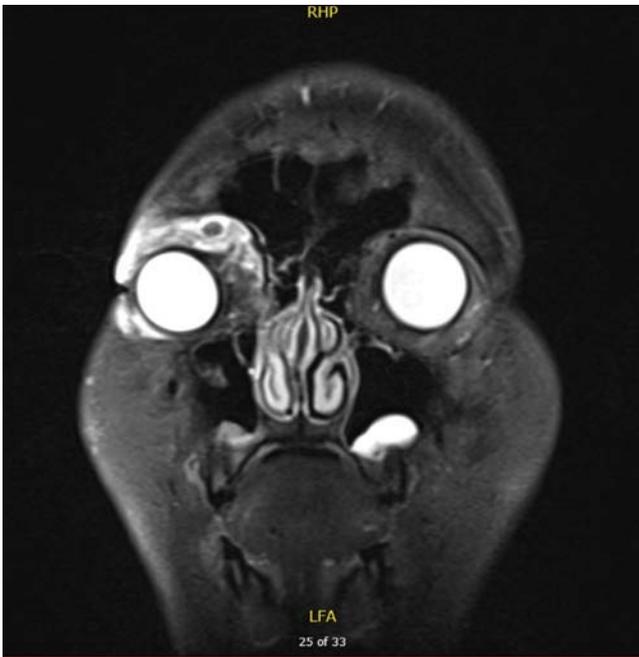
T2-weighted, coronal-cut magnetic resonance imaging demonstrating significant reduction in the pseudomeningocele, now measuring 3.2 × 1.6 × 0.9 cm, and decreased proptosis. This image was taken 1 day after surgery.
